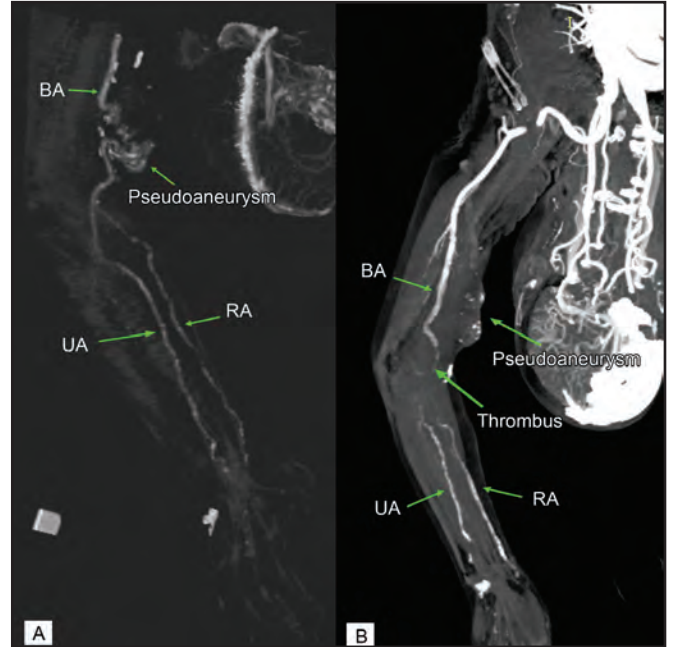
CTA Images showing thrombosed right BCF. Patent brachial artery down to a proximal third of radius ulnar artery on delayed images. Faint opacification was seen distal to it due to heavy calcification (A), thrombosed right BCF with non-opacification in distal brachial artery measuring 2.7cm in length (B)
